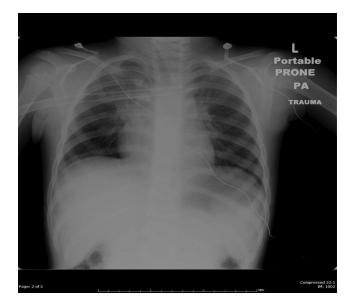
Initial chest roentgenogram showing the needle traversing the mediastinum.
